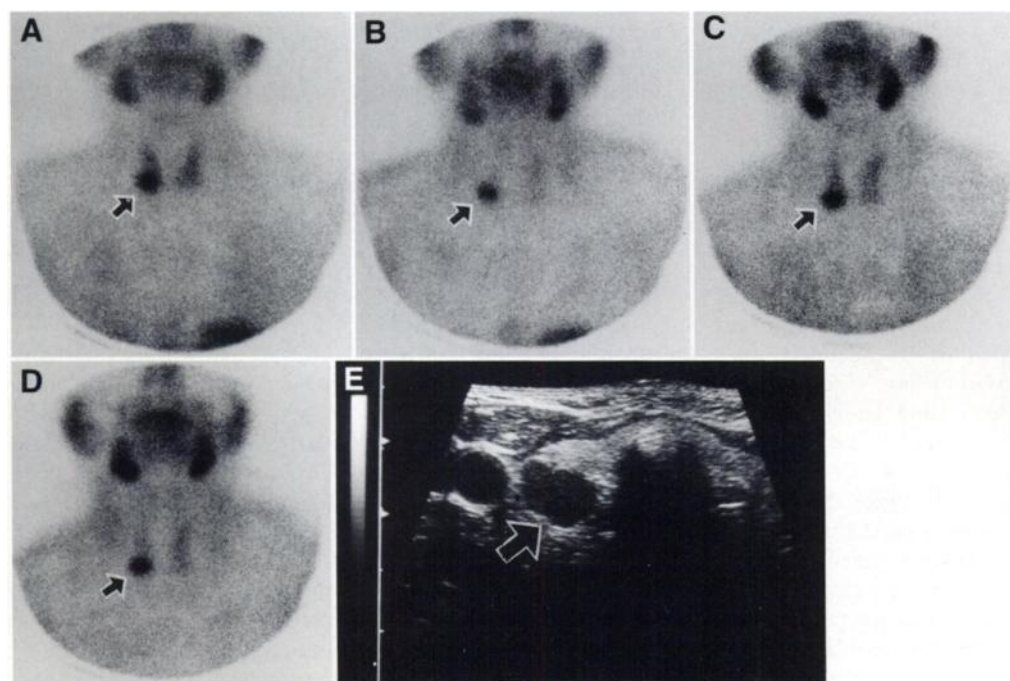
A 65-yr-old woman with hyperplastic parathyroid glands. Technetium-99m-MIBI imaging: (A) Early image showing an uniform thyroid uptake with a more intense focal uptake (arrow) in the right lower neck. (B) Late image showing decreased thyroid uptake and focal uptake (arrow) in the right lower neck. Technetium-99m-tetrofosmin imaging: (C) Early image showing increased thyroid uptake associated with focal uptake (arrow) in the right lower neck. (D) Late image demonstrating intense focal uptake (arrow) in the right lower neck. (E) Ultrasonography demonstrating the parathyroid gland as a hypoechoic mass (arrow). The weights of four hyperplastic parathyroid glands ranged from 0.33–2.1 g.
